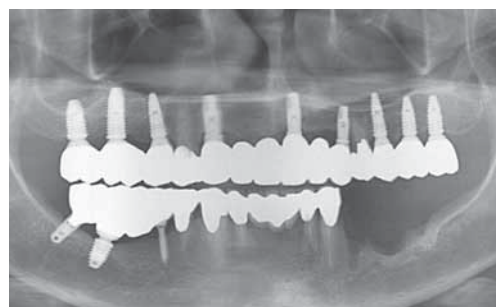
Postoperative radiographic view.
